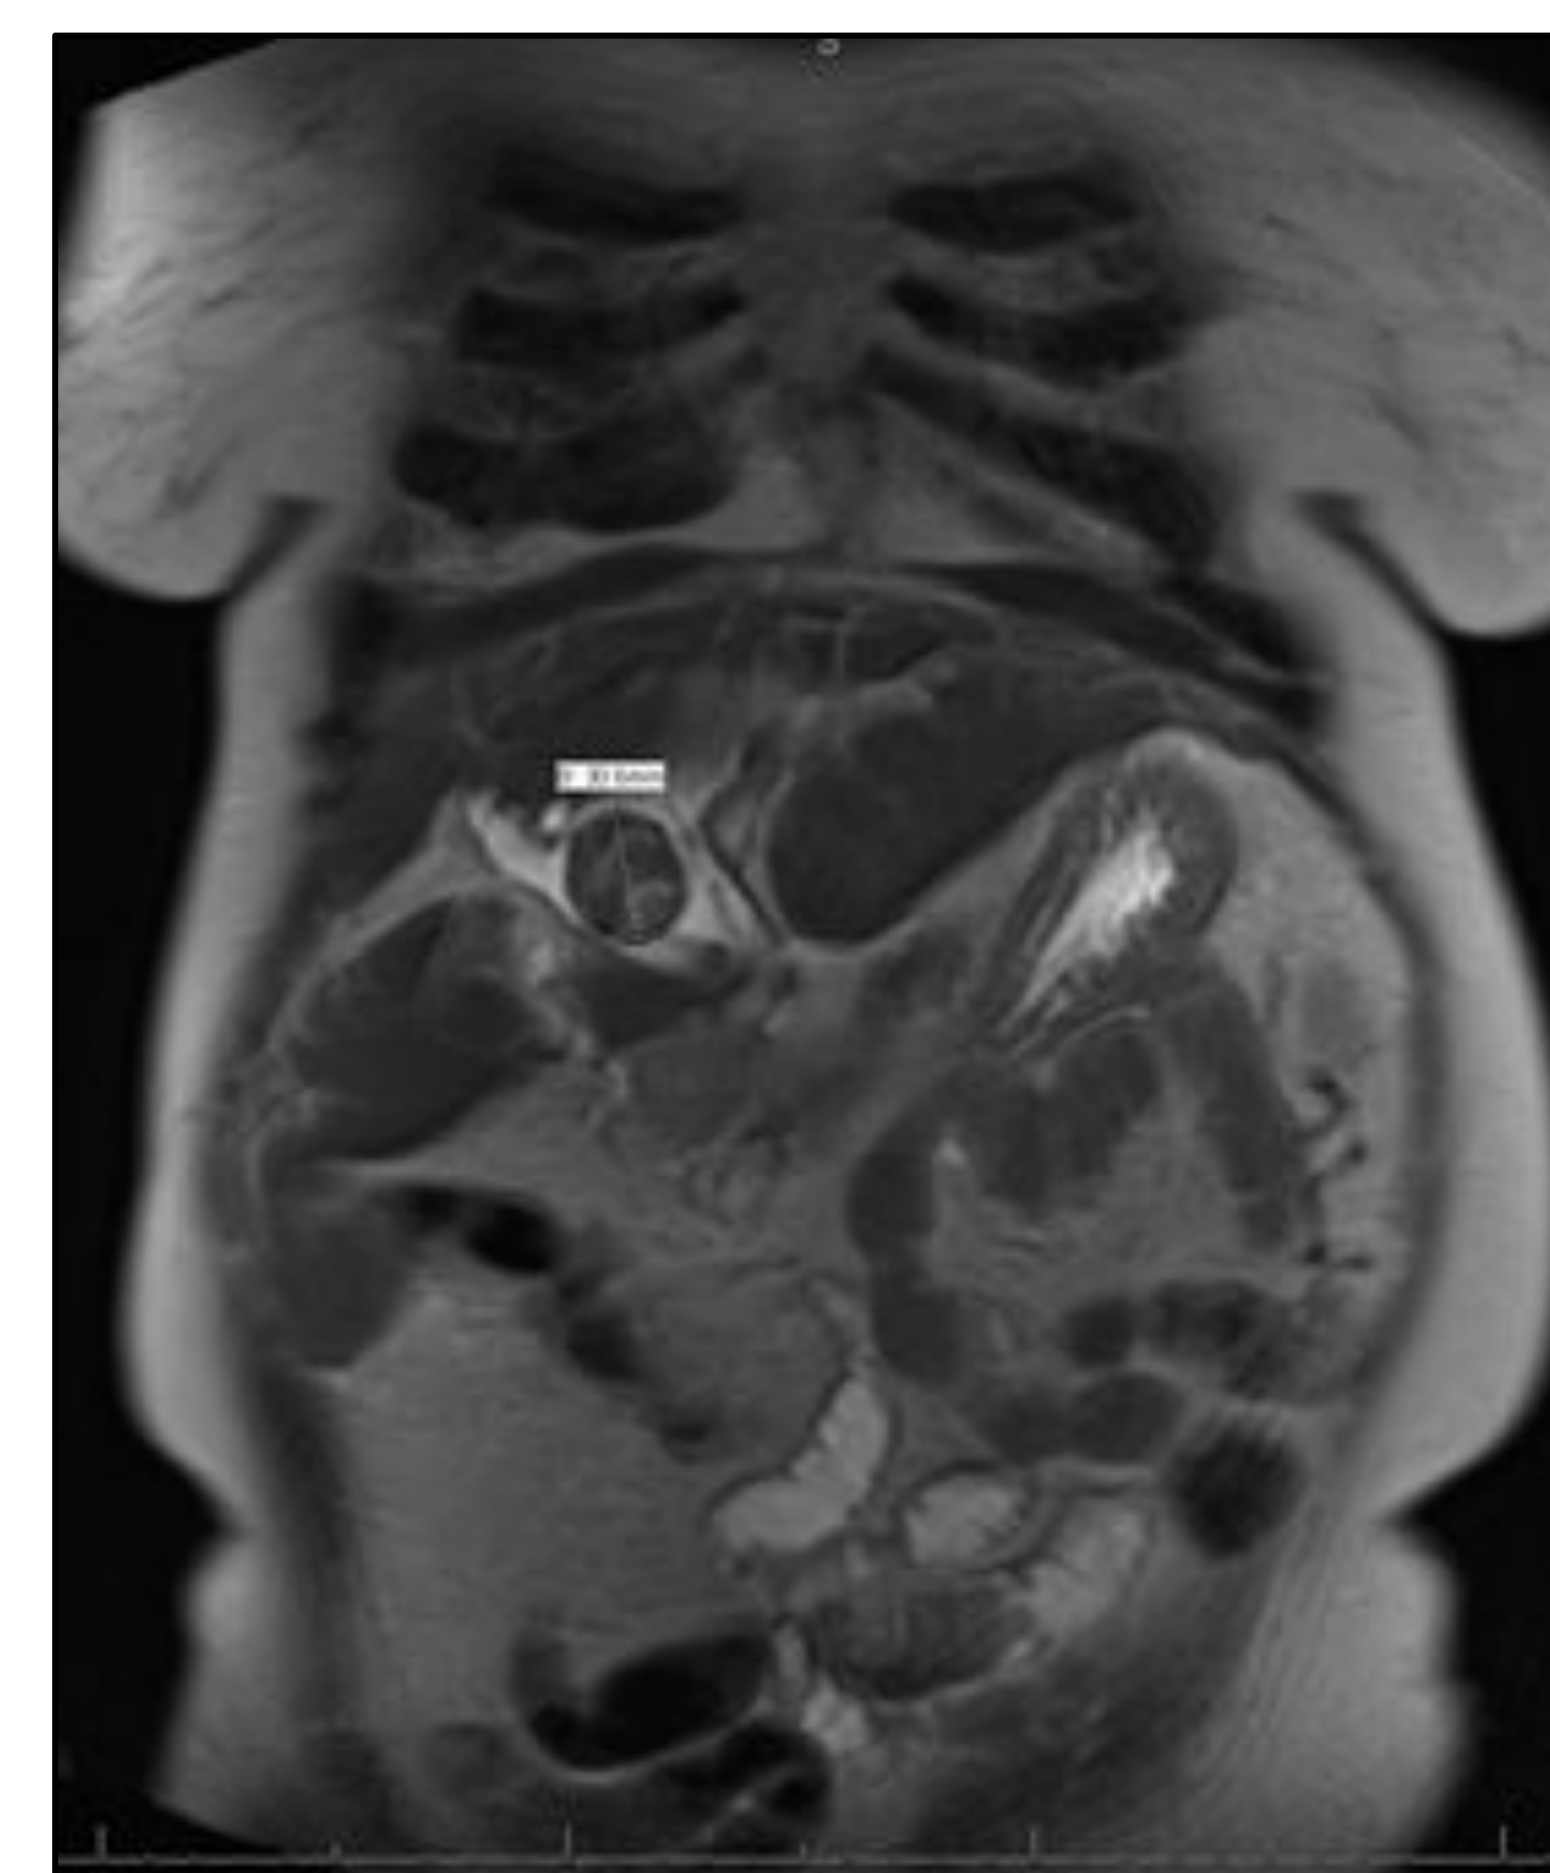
MRI demonstrating a large 3 cm choledocholithiasis within the dilated CBD
